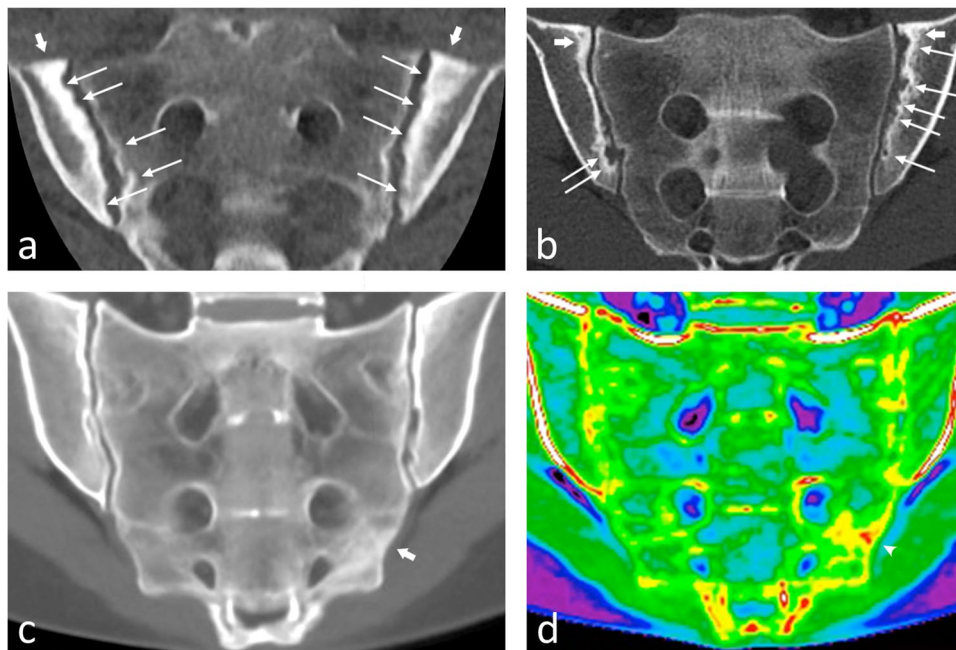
Imaging examples of CT findings of the sacroiliac joints. a A 33-year-old male patient with axial spondyloarthritis and erosive sacroiliitis underwent low-dose CT of the sacroiliac joints, reconstructed with artificial intelligence. Despite a volume CT dose index (CTDIvol) of 0.3 mGy and dose length product (DLP) of 2.6 mGy*cm, sufficient image quality was achieved, showing sclerosis (short arrows) and erosion (long arrows), resulting in pseudo widening of the joint. b A 27-year-old man with known axial spondyloarthritis and bilateral sacroiliitis. Standard-dose CT with iterative reconstructions shows extensive erosions (long arrows) and bilateral sclerosis (short arrows). c Coronal oblique 70 kilo-electron-volt virtual monochromatic CT image and (d) corresponding color-coded dual-energy CT image (post-processing with virtual non-calcium reconstruction using a three-material-decomposition) of a 46-year-old female patient with chronic back pain after falling with the bicycle. While standard CT shows a mild sclerotic area (short arrow) but no cortical disruption, dual-energy CT reveals bone marrow edema (arrowhead) in a medullary bone fracture
